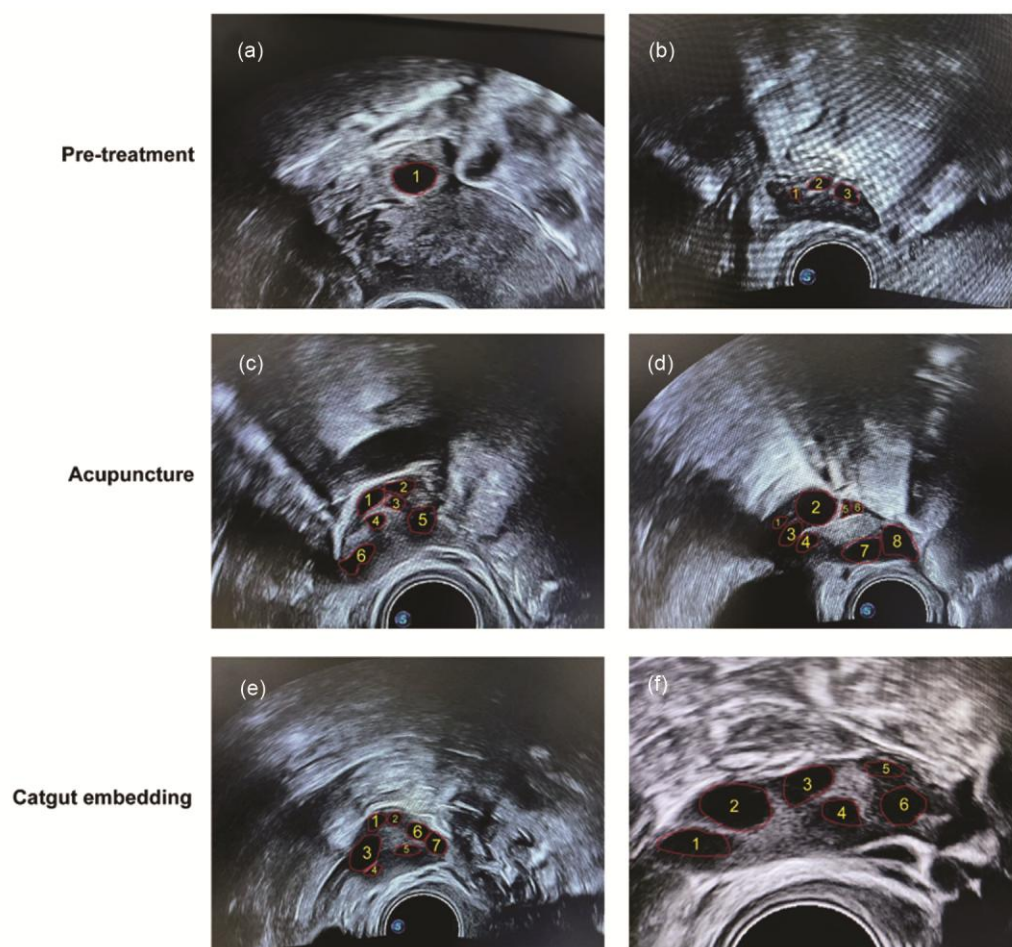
Representative images of ultrasound probing of antral follicle count, (a) and (b), pre-treatment, (c) and (d), after 12 weeks of acupuncture treatment, (e) and (f), after 12 weeks of acupoint catgut embedding treatment
